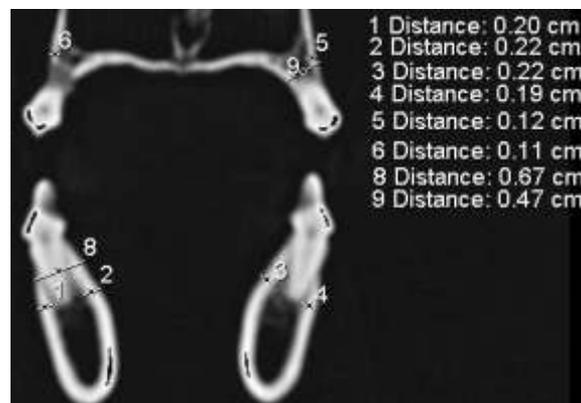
CT - coronal section through maxilla and mandible with the measurements of predetermined parameters.
